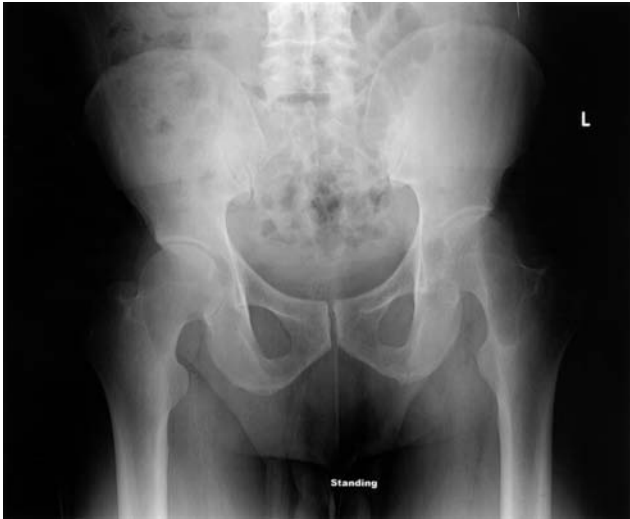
Radiograph of the pelvis shows the sharply marginated left femoral neck lesion without sclerotic margins.
